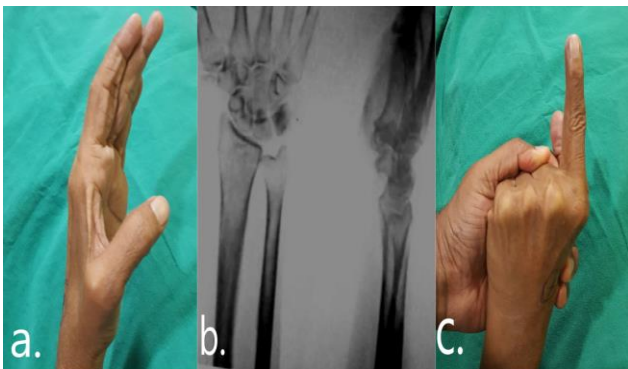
(A-C): Pre operative picture, plain X-ray and independent extension of the index finger, (A) unable to extend the thumb with flexion attitude of MCP and IP joint, 1 (B) X-ray showing nondisplaced fracture of distal radius with involvement of Lister's tubercle, (C) independent extension of the index finger (pre op. confirmation).
